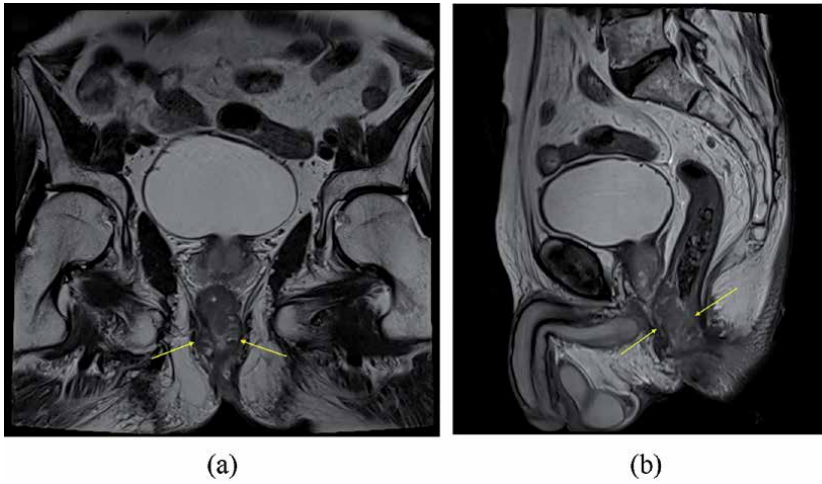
Low-lying rectal cancer. (a) T2 weighted image on MRI. Coronal view. The low-lying rectal cancer invades internal anal sphincter. (b) T2 weighted image on MRI. Sagittal view.*
